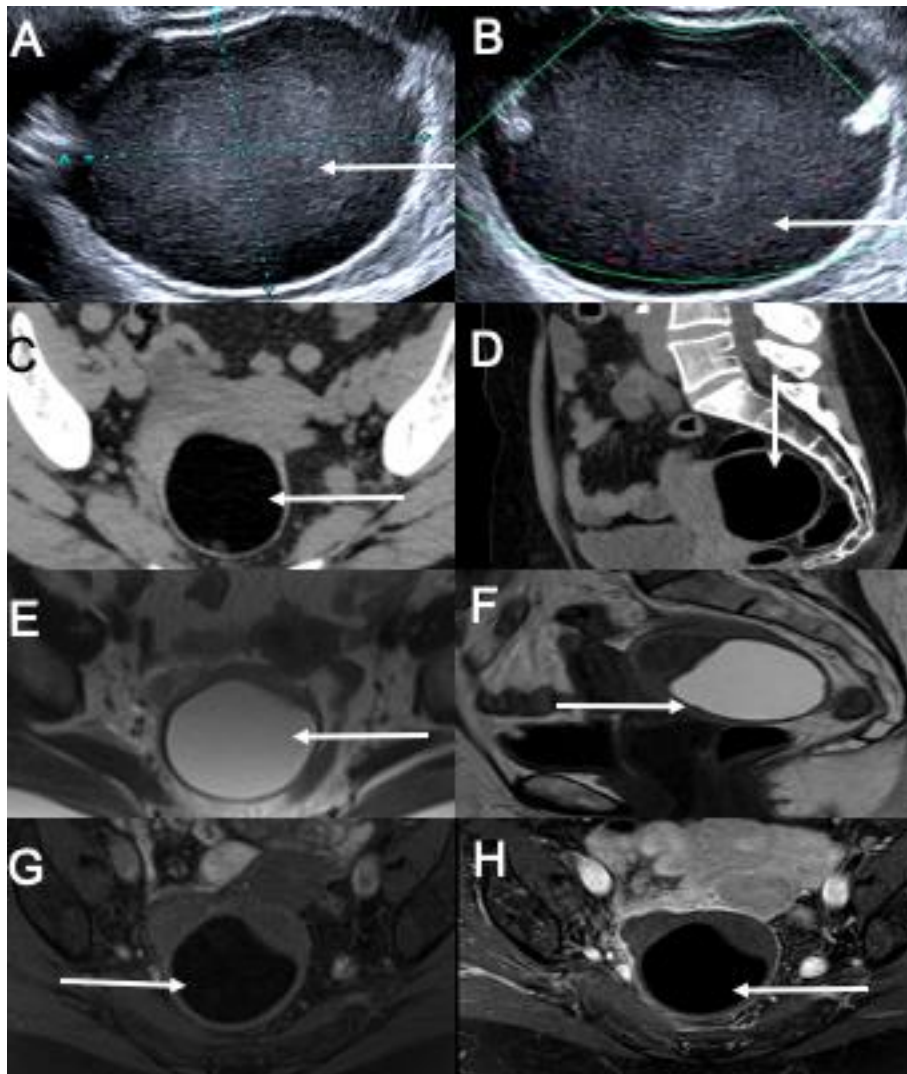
Features of fat tissue in the different radiological modalities (long arrows). US shows a unilocular cystic lesion diffusely echogenic (A) without flow in the Doppler exam (B). On CT (C, D), it has a similar density to the subcutaneous and visceral fat. Moreover, on MR, it is hyperintense on T2-weighted (E) and T1-weighted (F), with loss of signal in T1-fat suppression (G-H).
